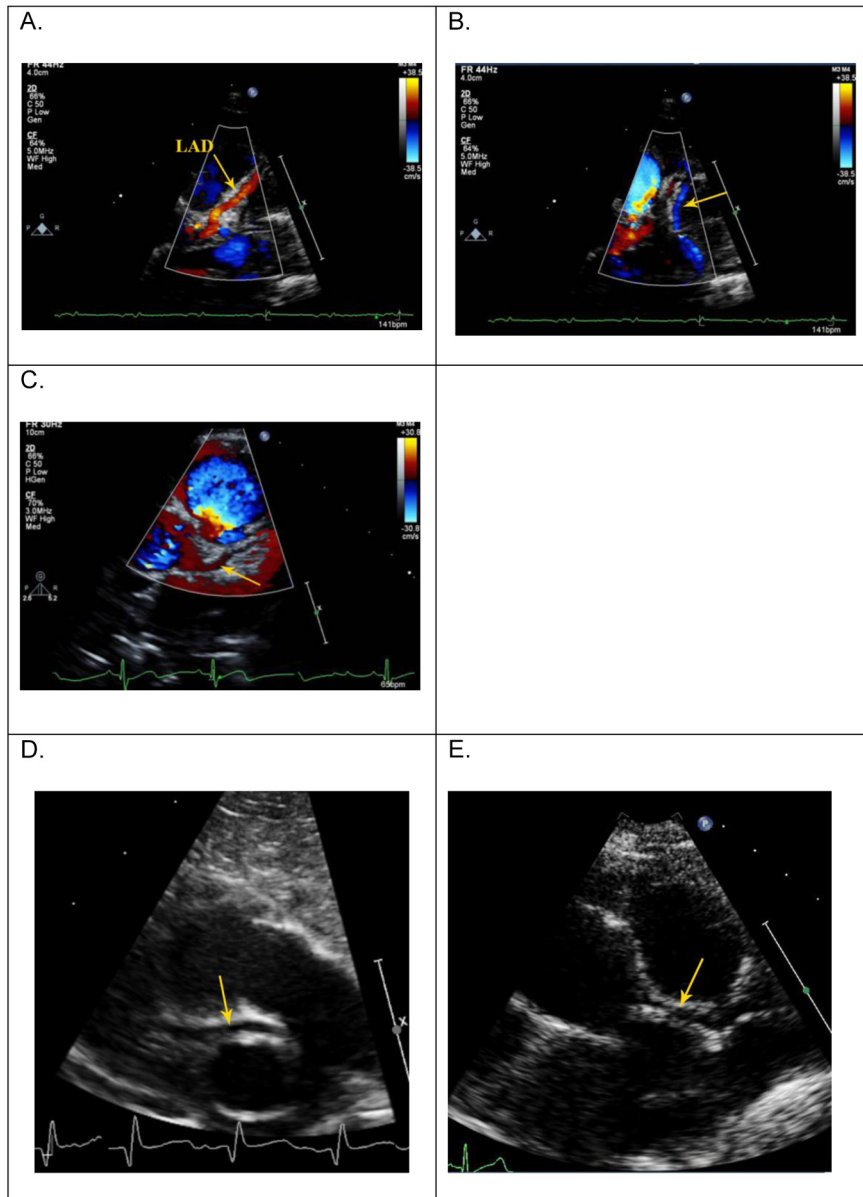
Example of a normal color Doppler signal in the left anterior descending coronary artery (LAD) and left circumflex coronary artery during diastole (A) and the great cardiac vein during systole (B). Left coronary artery flow during systole (C) along with color artifact in the surrounding tissue provides images that are not diagnostically convincing. Small amounts of fluid in the pericardial sinuses near the RCA (D) and left (E) coronary arteries can be mistaken for coronary vessels. See [Videos 1A, 1B, and 1C](#) (available at www.onlinejase.com).
